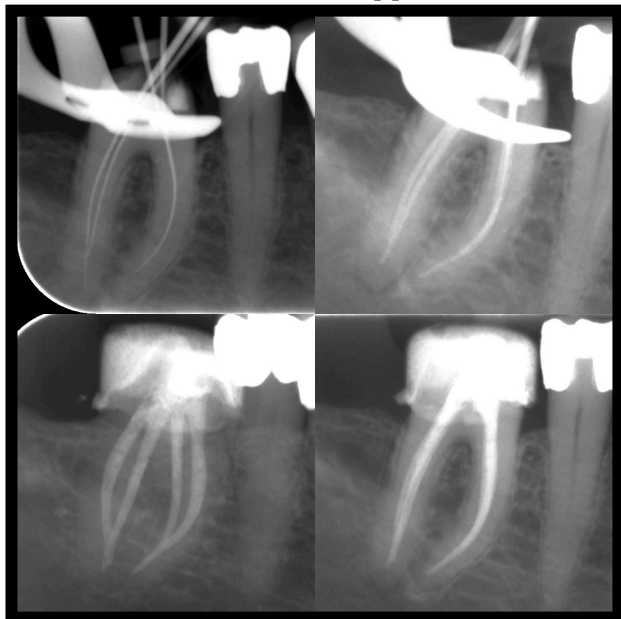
Treatment radiographs 46; Top: Working length and masterpoint. Bottom: Mesioeccentric and orthoradial posttreatment
